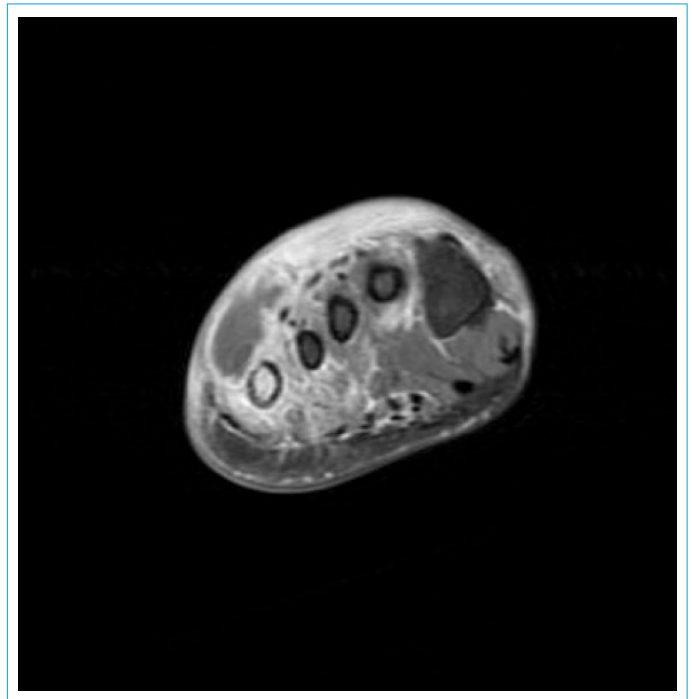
MRI findings consistent with osteomyelitis in the 4th and 5th metatarsals of the right foot.
